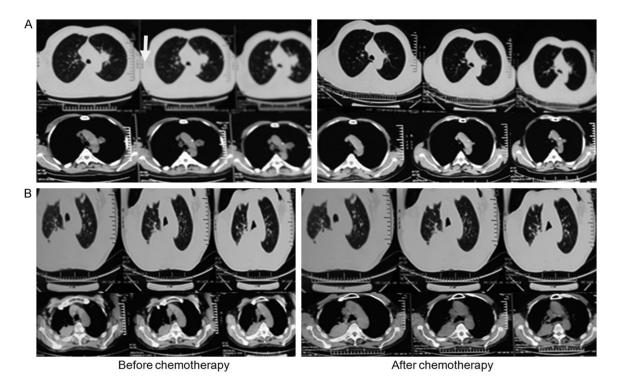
Two cases of non-small cell lung cancer before and after chemotherapy in patients with chest CT images. A: Typical Case 1: After chemotherapy, CT image changes show left lung tumor after chemotherapy significantly narrowed (response: PR); B: Typical Case 2: After chemotherapy, CT image changes mean right lung tumor increased (response: PD).
